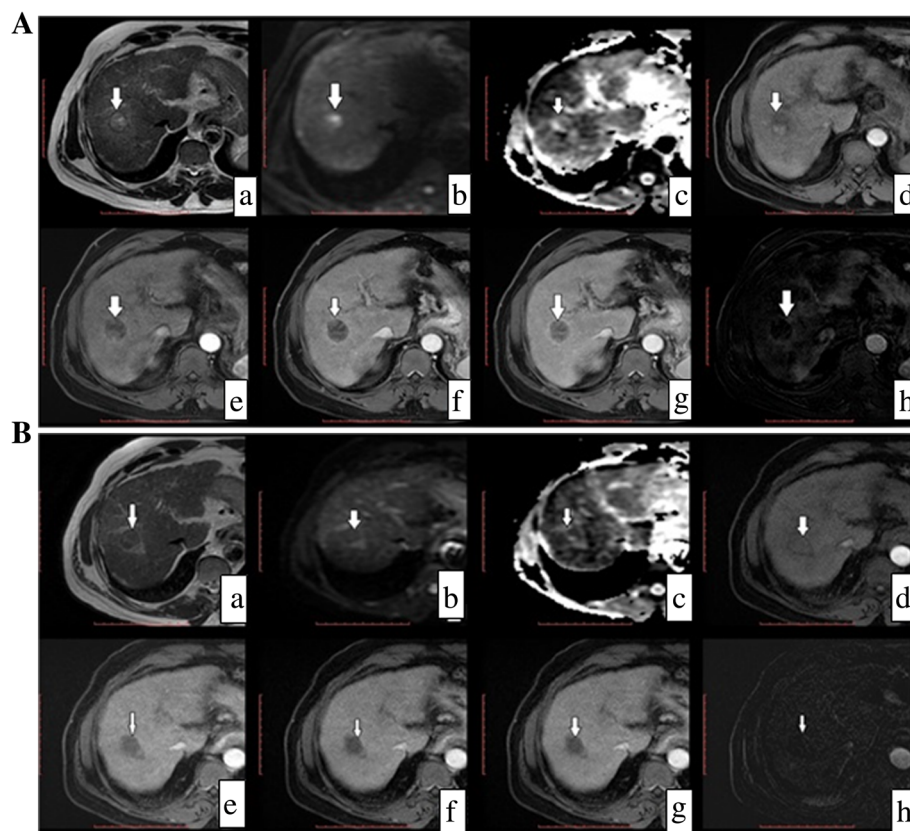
A 55-year-old male patient with hepatitis-related liver cirrhosis and single segment VIII HCC lesion. He had a TACE session and came for follow up 1 and 3 months later. (A) Follow up dynamic MRI 1 month post TACE. a T2WI, b DWI image, c ADC image, d T1WI, e late arterial phase, f portal phase, g delayed phase, and h late arterial subtracted image. The treatment zone exhibits high signal in T1WIs and mildly increased signal in T2WIs with peripheral marginal enhancement. Subtraction removed the central high signal thus excluding residual disease. (B) Follow up dynamic MRI 3 months post TACE. a T2WI, b DWI image, c ADC image, d T1WI, e late arterial phase, f Portal phase, g delayed phase, and h late arterial subtracted image. Note that the lesion became of low to intermediate signal in T2WIs and iso to high signal intensity in T1WIs. The marginal enhancement became inconspicuous. High signal that was detected on the DWI is decreased in the follow up. No enhancement detected at the subtraction images confirming the complete response
